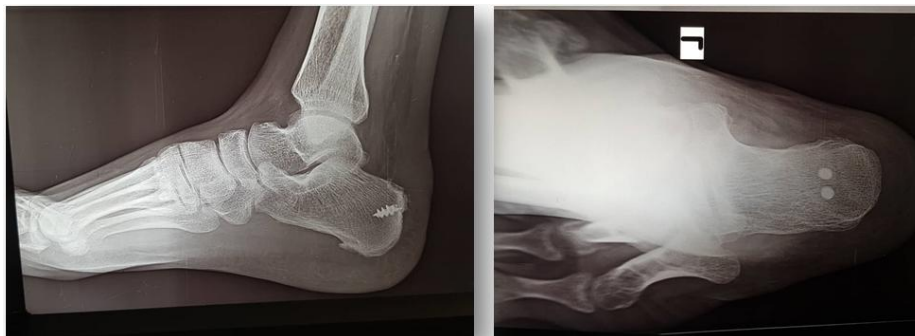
Postoperative radiographic picture of ankle (lateral and axial harris view) showing anchor
